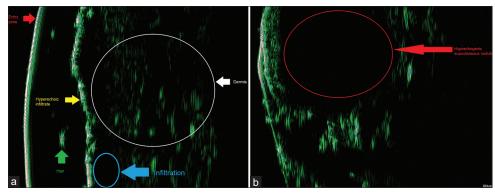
(a) Massive infiltration in the dermis (sonographic picture). (b) Sonographic feature of the neurofibroma in the skin.
